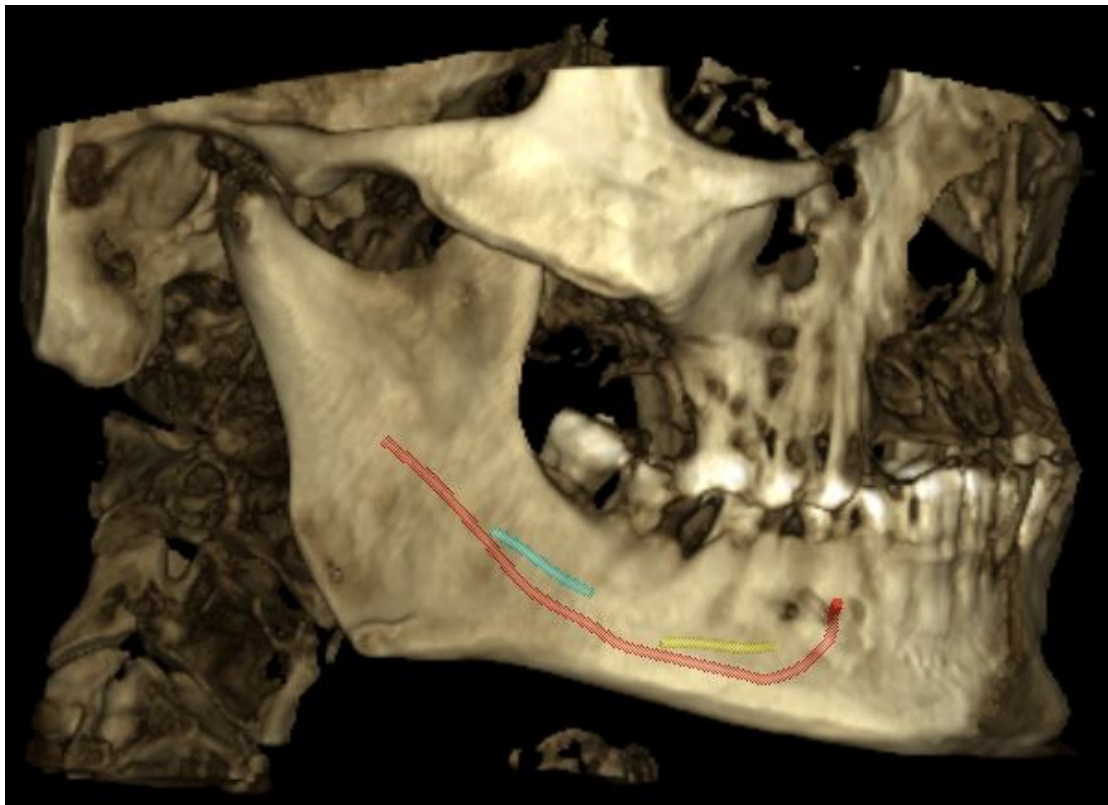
3-D reconstructed CBCT image with tracing of the MC showing trifurcation and the openings of MF and two AMF on the right side.
